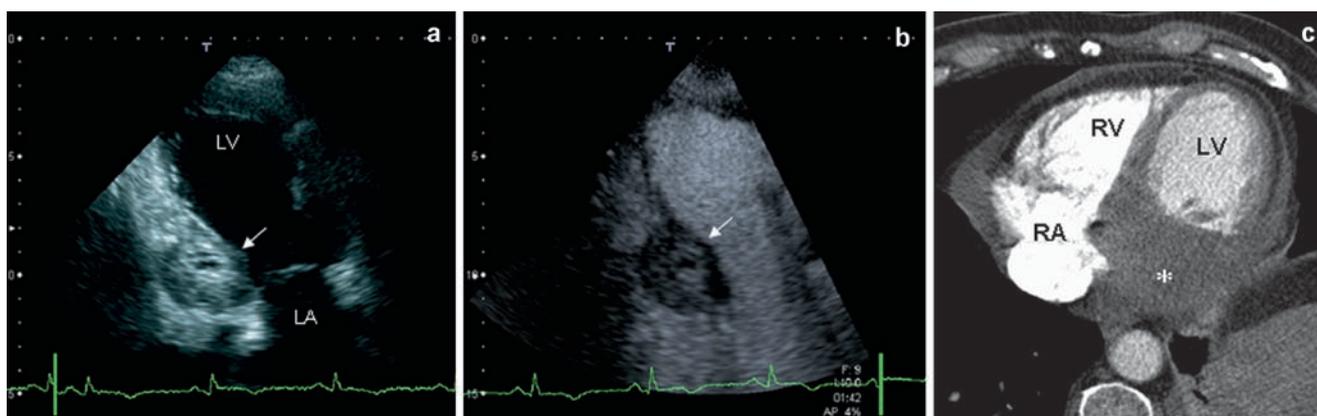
Cardiac metastasis of urothel carcinoma in a 70-year-old male patient. In trans-thoracic echocardiography, the metastasis located in the basal inferior wall of the left ventricle (*arrow*) appears with a typical pattern of a hypo-dense outer region that is clearly demarcated from myocardial tissue and a hyper-dense central region
